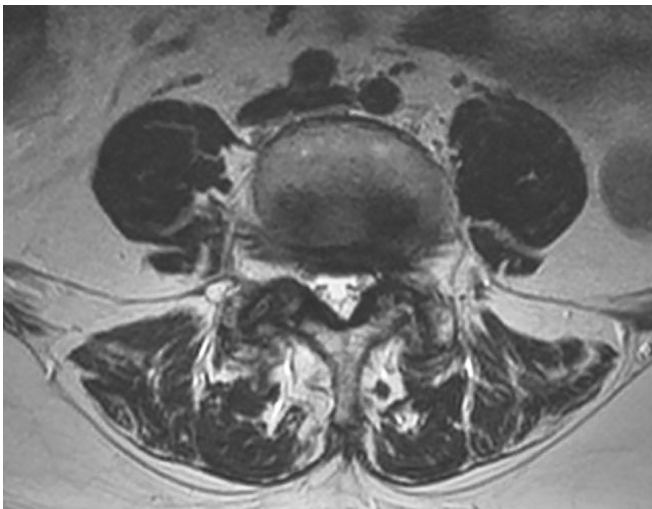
Axial sections of Lumbar spine MRI
